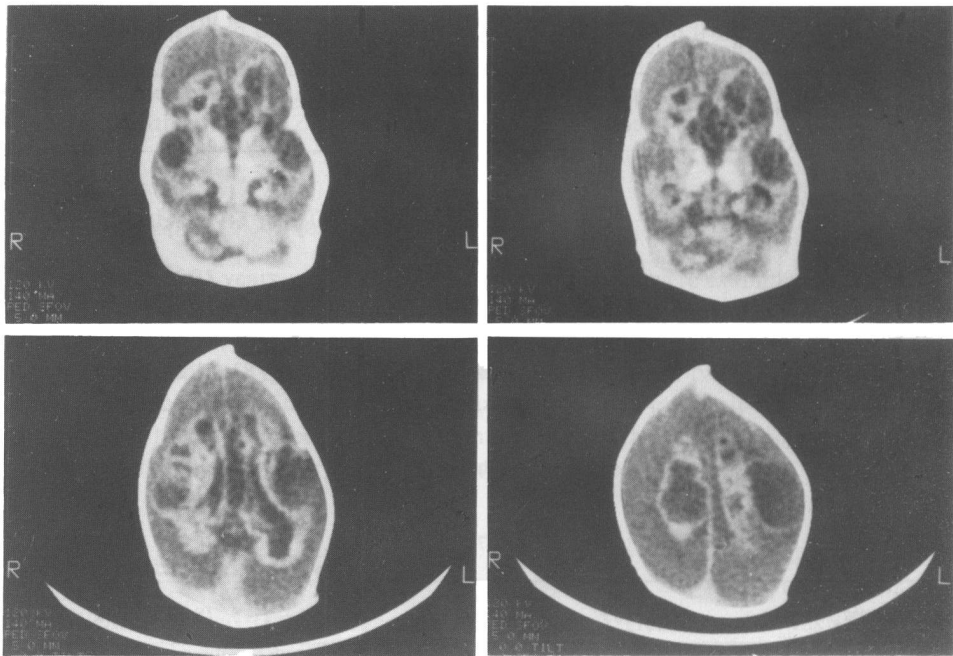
CT-scan of brain at 7 weeks old. Porencephaly due to multiple infarctions is noticeable.
